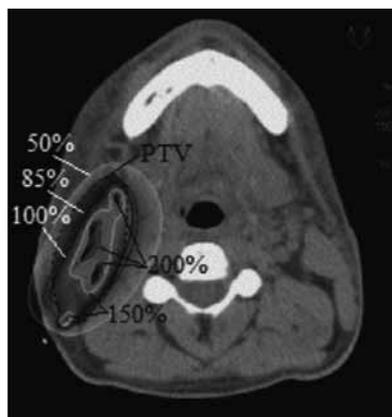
Axial CT-image showing the PTV (dotted line) with values of isodoses.
